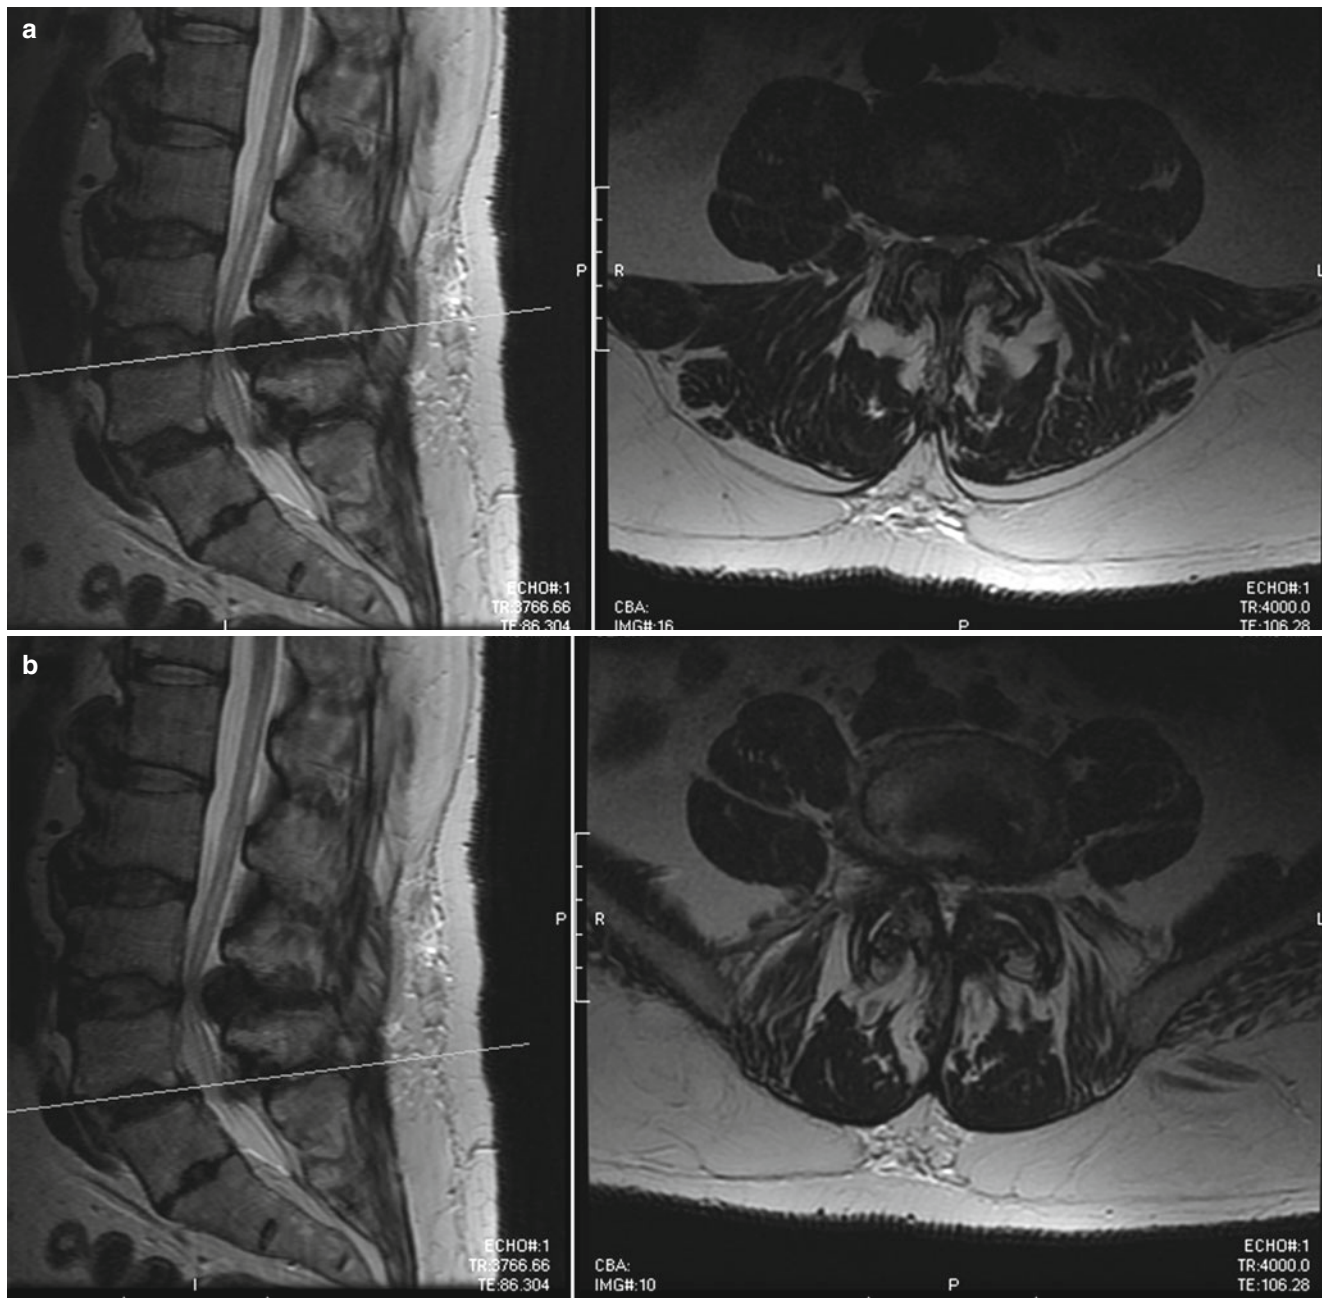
A 66-year-old male presenting with neurogenic claudication with good relief of his symptoms upon forward flexion. His radiographic studies demonstrate a degenerative spondylolisthesis at L4–5
